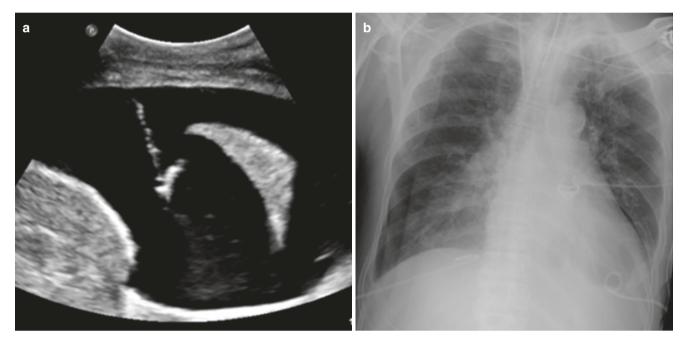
Pleural drain for pleural effusion. (a) Ultrasound image after image-guided insertion of the pleural drainage catheter. A large anechoic pleural effusion is seen with collapsed lower lobe and an
